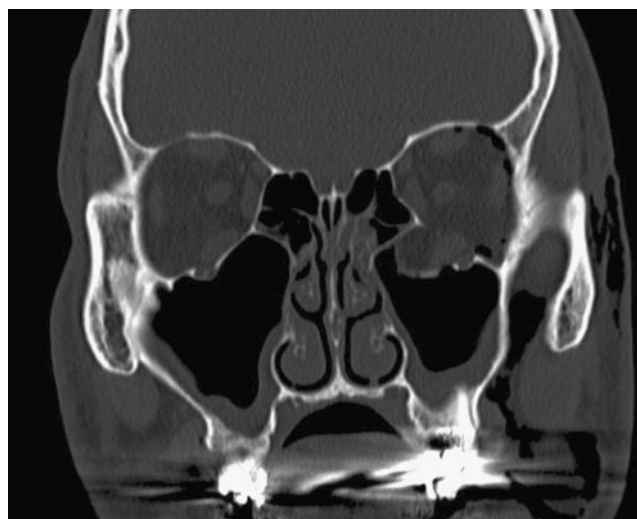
Coronal CT scan with burst type fracture without muscle or tissue strangulation
